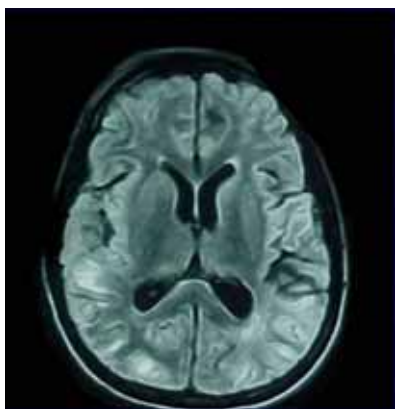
Axial fluid attenuated inversion recovery MR image showing multiple confluent lesions involving the gyri and subcortical white matter both insular, parietal, frontal and occipital lobes.
